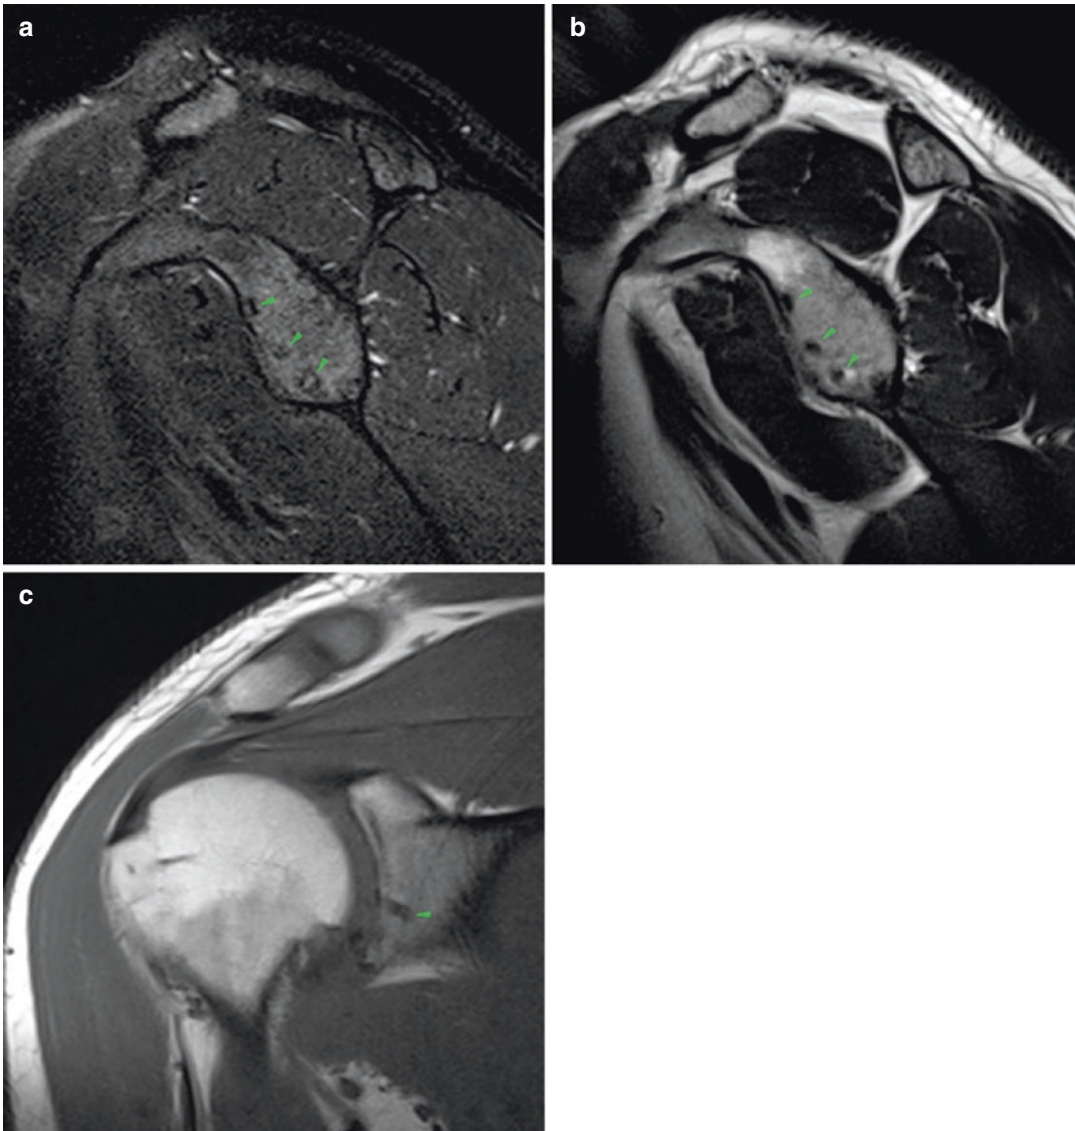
(a–c) Nonmetal suture anchor post arthroscopic repair of a Bankart lesion with bioabsorbable suture anchors. (a) T2-weighted FatSat sagittal MR image. The suture tracks are readily appreciated with normal appearance (arrowheads). (b) T2-weighted MR image, nonfat saturated.
